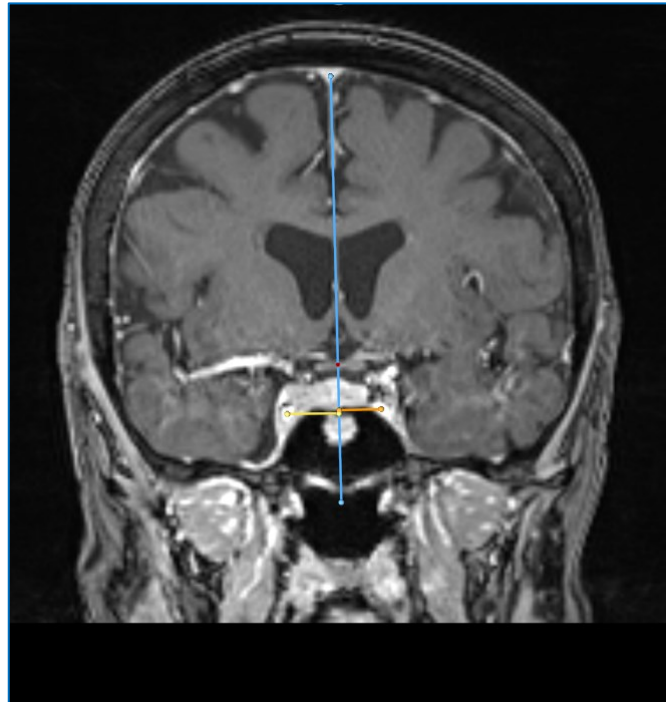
Coronal T1-weighted contrast-enhanced MRI-scan. Measuring the displacement of the cavernous ICA with a midsella coronal section T1- MRI-scan using the Medtronic S8 Navigation system (Medtronic, Colorado, USA). Yellow - distance left 14.4 mm, Orange - distance right 11.6 mm.
